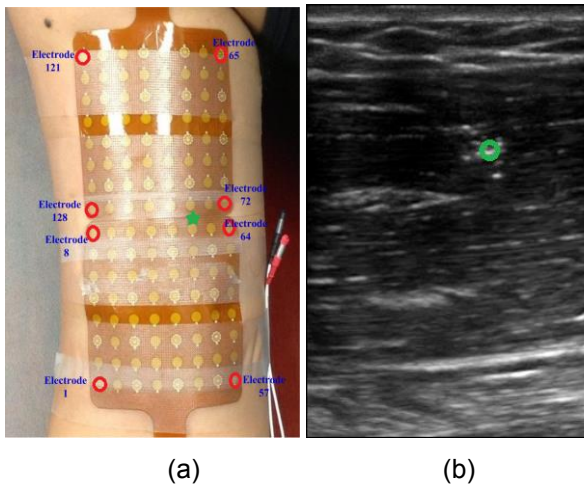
(a) shows the relative position of surface EMG electrodes and wire electrode (green star) over the subject's right upper arm. (b) shows the location of the wire electrode (green circle) in the ultrasound image of the upper arm.
